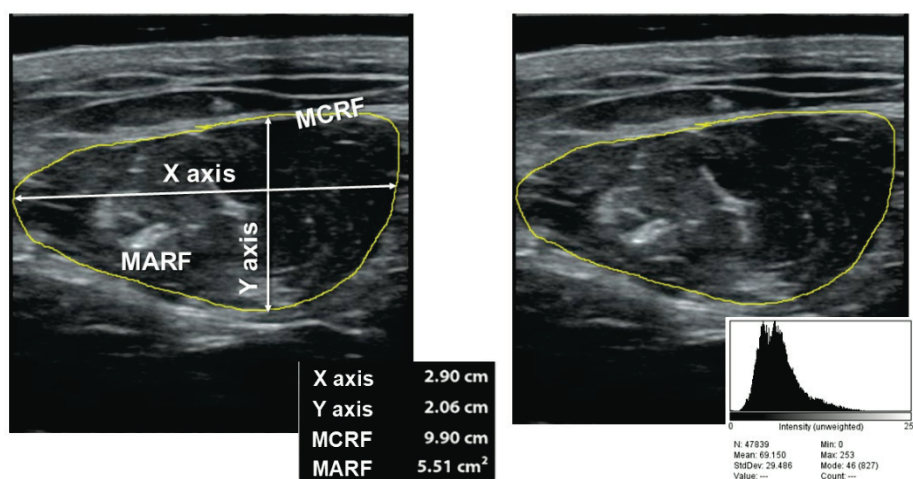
Parameters of muscle ultrasonography of quadriceps rectus femoris ((right) muscle mass measures; (left) echogenicity). MARF: Muscular Area Rectus Femoris; MCRF: Muscular Circumference Rectus Femoris.
